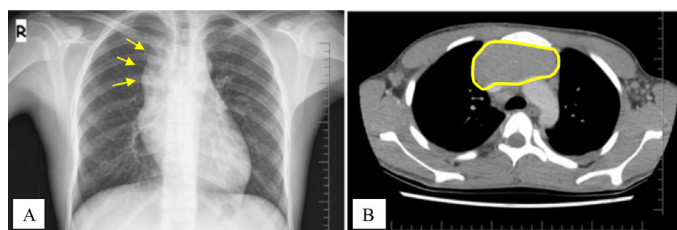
A) Increased thymus shadow on X-ray, B) Soft tissue density (enlarged thymic tissue) that completely fills the anterior mediastinum on computed tomography
